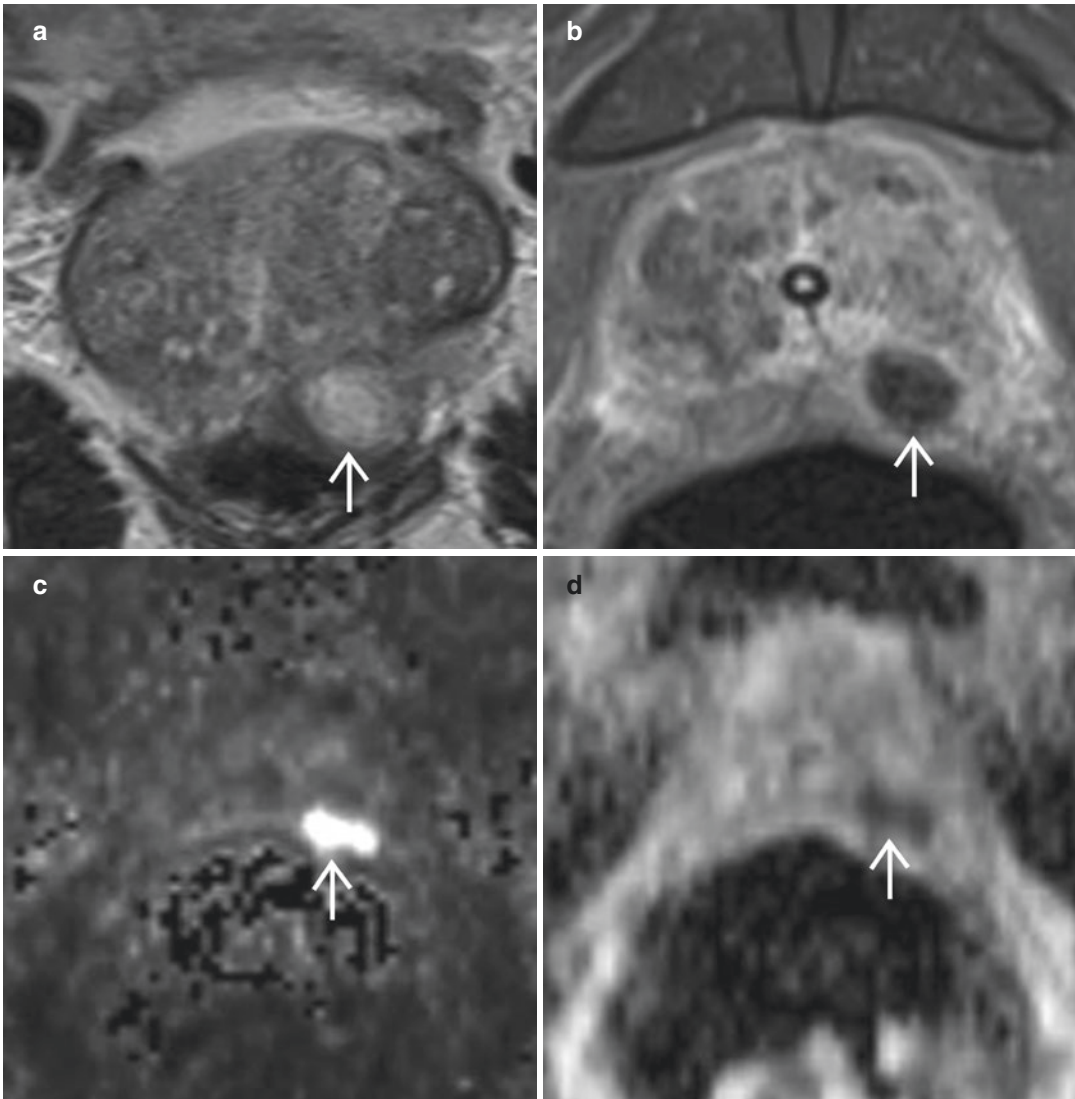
Prostatic TB with abscess formation in a 72-year-old man who had TB epididymo-orchitis and mild raised serum prostate-specific antigen (10.7 ng/mL). (a) Coronal T2-weighted and (b) axial contrast-enhanced fat-suppressed T1-weighted MR images show a round
